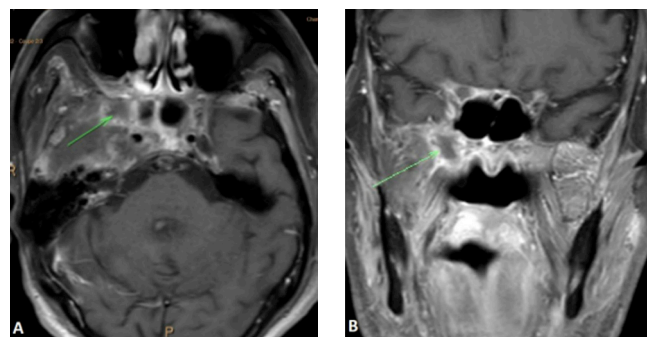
(A,B): Follow up MRI of the neck passing through the cavum showing a tumor process of the right lateral wall of the nasopharynx (green arrow).
